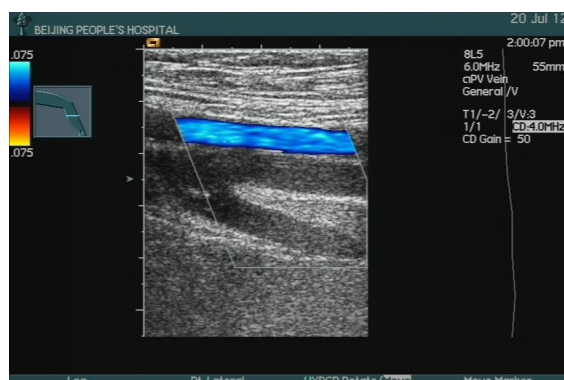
The ultrasonic blood flow imaging of the right femoral artery and femoral veins induced by oral administration of CBZ. The upper wide blue strip blood flow imaging showed the patency of the right superficial femoral artery, and the lower Y-shape black and white areas were right general, superficial and deep femoral veins, respectively, in which there were thrombosis
